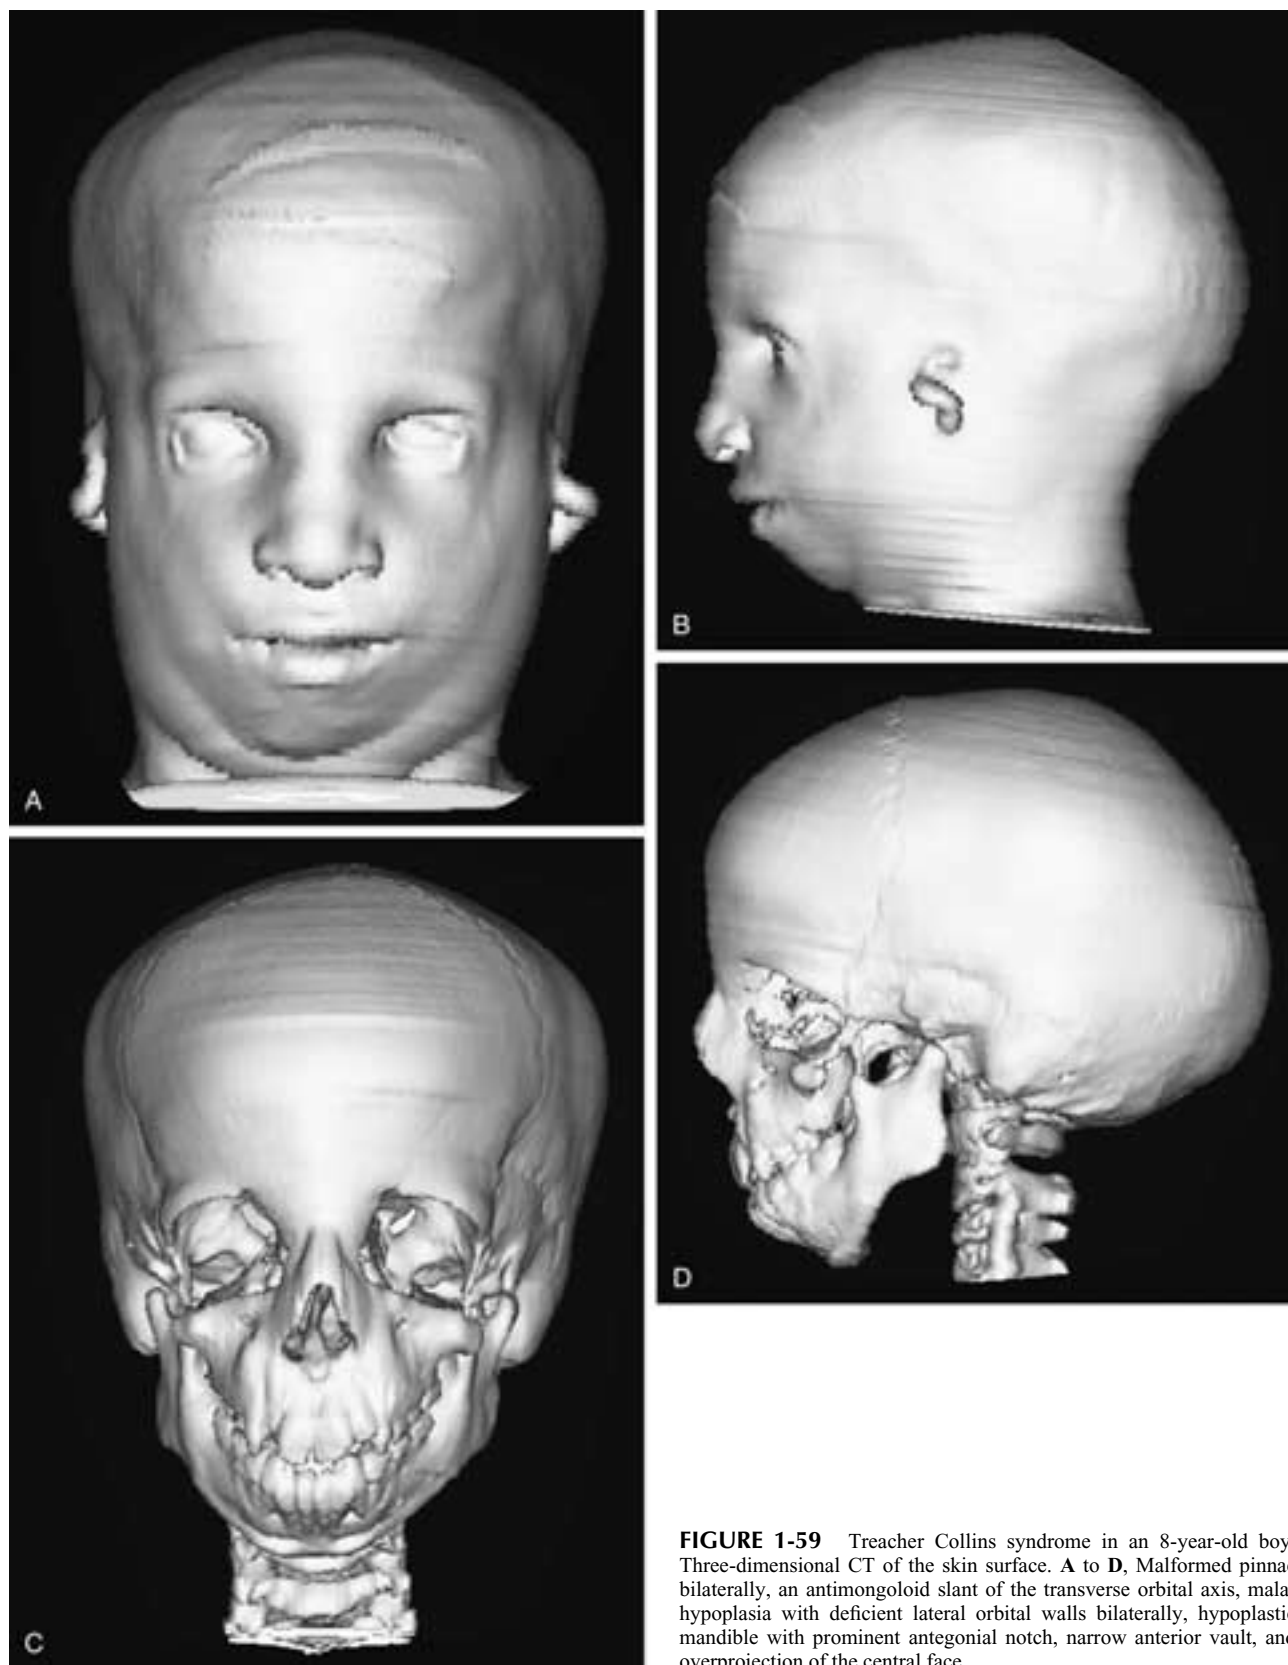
Treacher Collins syndrome in an 8-year-old boy. Three-dimensional CT of the skin surface. A to D, Malformed pinnae bilaterally, an antimongoloid slant of the transverse orbital axis, malar hypoplasia with deficient lateral orbital walls bilaterally, hypoplastic mandible with prominent antegonial notch, narrow anterior vault, and overprojection of the central face.
